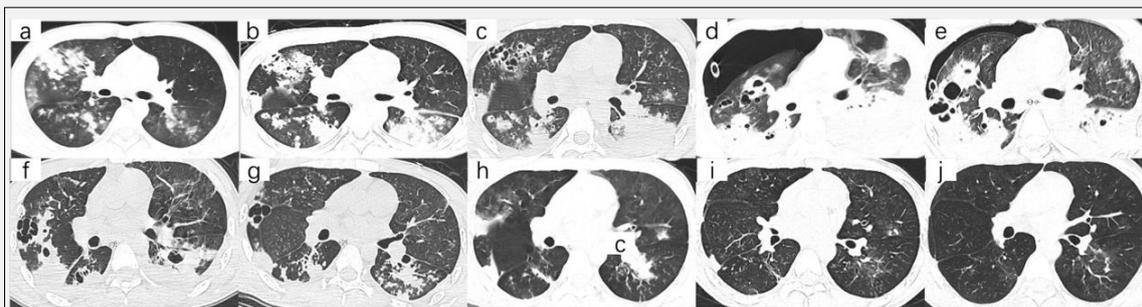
Chest CT Scans: a Admission day 1, b Admission day 4, c Admission day 7, d Admission day 11, e Admission day 15, f Admission day 18, g Admission day 22, h Admission day 32, i Admission day 37, j Post-discharge day 30 demonstrated resolution of bilateral pulmonary consolidations, nodular opacities, and exudative shadows compared with prior imaging, with coalescence and reduction in size of cavitary lesions.
